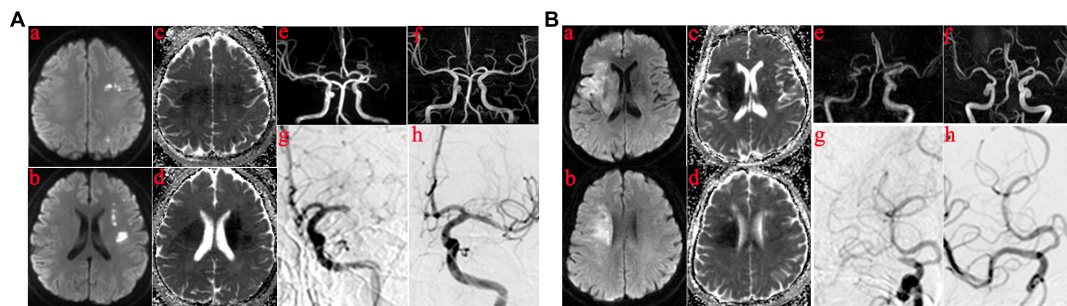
Those in whom the infarct core was mainly in the basal ganglia or semiovoid region and those in whom the infarct core was mainly in cortex. (A) The infarct core was mainly in basal ganglia or semiovoid region. (a–d) The presentation of infarcts on DWI and Apparent diffusion coefficient (ADC) mapping; (e) Right middle cerebral artery occlusion before operation on MRA; (f) MRA performed within 1 week showed severe residual stenosis in the responsibility lesions of right middle cerebral artery; (g,h) DSA demonstrated the results of MRA. (B) The infarct core was mainly in cortex. (a–d) The presentation of infarcts on DWI and ADC mapping; (e) Left middle cerebral artery occlusion before operation on MRA; (f) Postoperative MRA showed no residual stenosis in the responsibility lesions of right middle cerebral artery; (g,h) DSA demonstrated the results of MRA.
